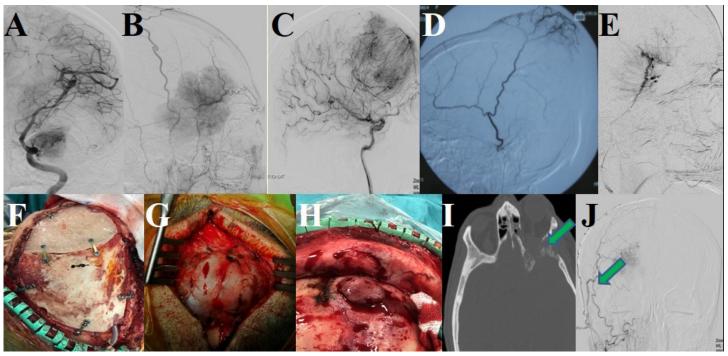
(A–C) Tumor vasculature in cranial digital subtraction angiography (DSA); (D) proper tumor embolization; (E) partial embolization; (F) reconstructed craniotomy area using the healthy remaining bone and PPMA patch; (G) tumor hyperostosis; (H) bone erosion; (I) bone erosion on computed tomography. (J) DSA showing the extracranial portions mostly fed by small distal branches of the external carotid artery.
